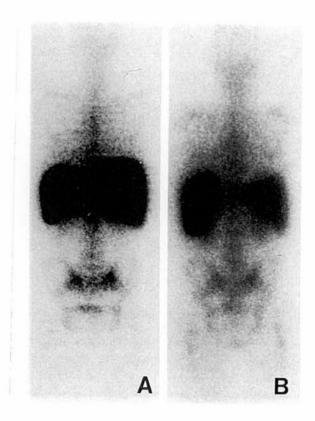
Regression of AL amyloidosis. Serial posterior whole body ¹²³I-SAP scintigraphs of a man with AL amyloidosis presenting with hepatomegaly and massive elevation of liver alkaline phosphatase. Initially (A) there was extensive uptake in the spleen, liver (largely obscuring renal deposits) and bone marrow. Remarkably, a second scan (B) performed 6 months later after 4 cycles of 'VAD' chemotherapy shows major regression of the liver deposits, associated with near normalisation of alkaline phosphatase, but little change in the splenic and bone marrow amyloid.
